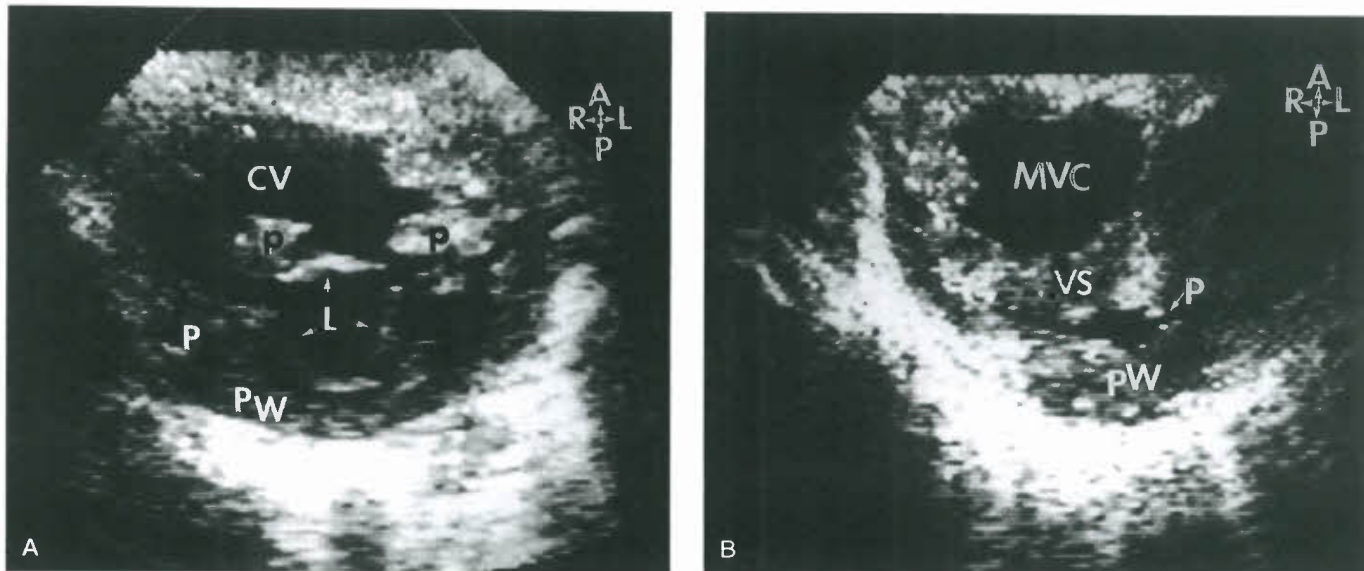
Parasternal short-axis scans demonstrating two examples of double-inlet right ventricle with a posterior hypoplastic LV. A: Hypoplastic LV (white P) posterior and to the right. B: Hypoplastic LV (P) posterior and to the left. The right-sided hypoplastic LV suggests that L-ventricular looping occurred, and the LV suggests a D-ventricular loop. In both cases, the AV valves were entirely committed to the main ventricular chamber (CV and MVC). L, left atrioventricular valve; black p, papillary muscle; PW, posterior wall; VS, ventricular septum.
